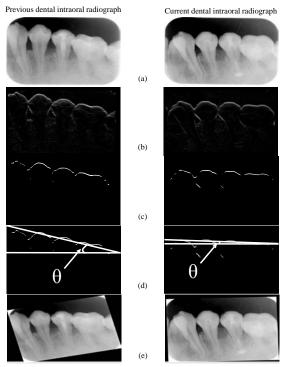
Correction of teeth axis direction: (a) original image,(b) Enhanced edges of teeth crowns, (c) Segmented edges of teeth crowns,(d) Approximate straight line, (e) Rotation of dental intraoral radiograph
